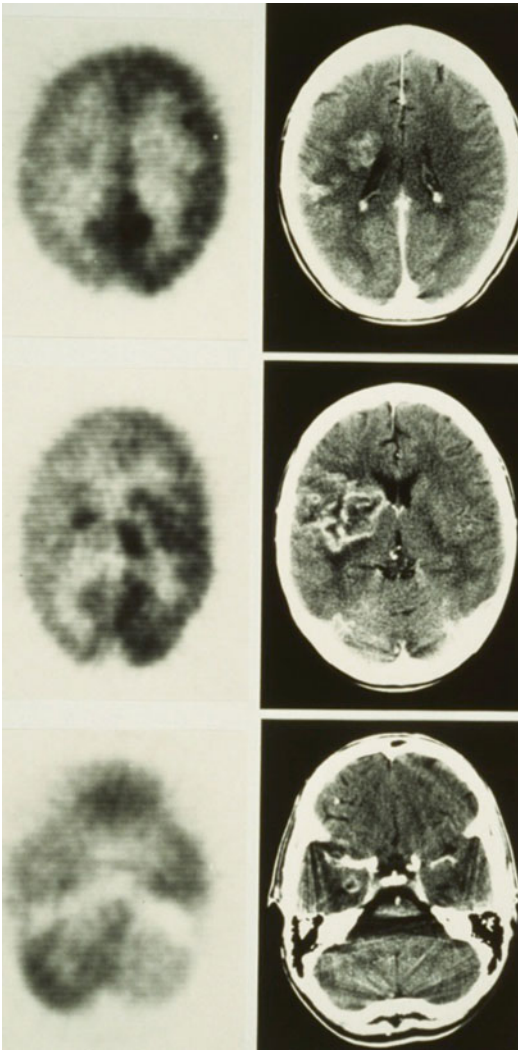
Case example: Bacterial brain abscess: A 29-year-old human immunodeficiency virus-negative intravenous drug abuser with a right hemispheric staphylococcal brain abscess underwent PET imaging of 18F-fluorodeoxyglucose (FDG) brain uptake. Diffuse right cortical hypometabolism was noted, as well as crossed cerebellar diaschisis. Unlike previous PET findings on FDG uptake in a brain abscess, the most intense uptake of FDG was found within the abscess and not in the contrast-enhancing walls
